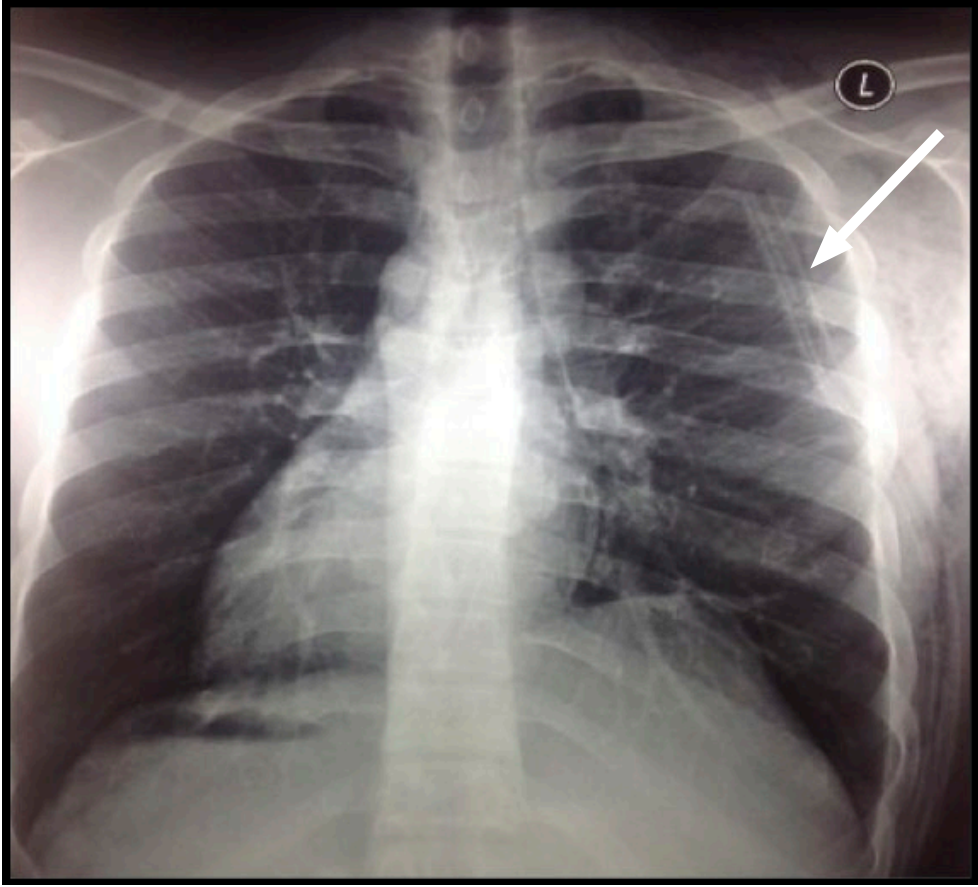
Chest X-ray (posteroanterior view) showing re-expansion of the left lung and resolution of the hemo-pneumothorax with the chest tube (white arrow) in-situ.
